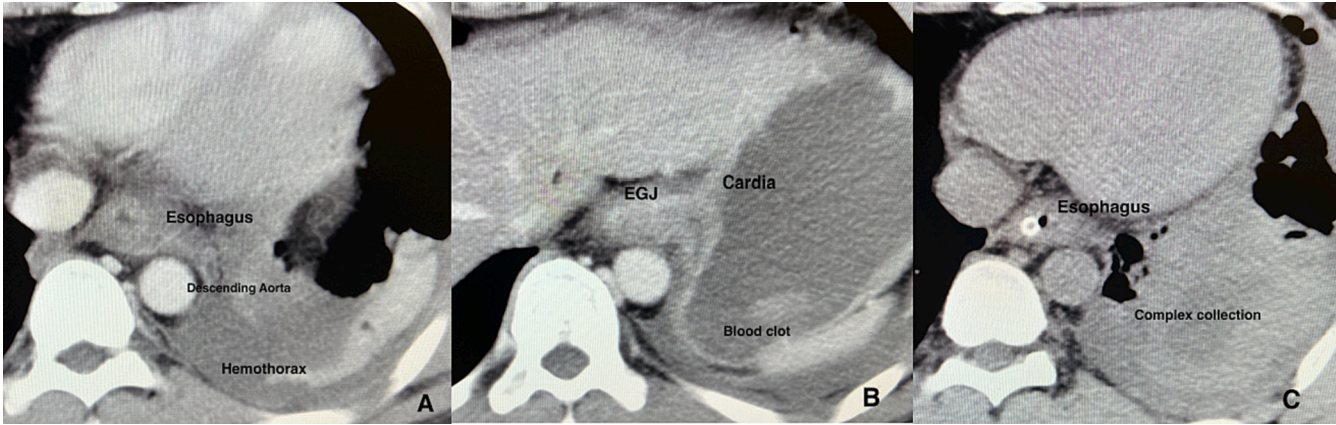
A-B: Initial CT scan (axial post-contrast), and C: 72-h post injury (axial non-contrast)
